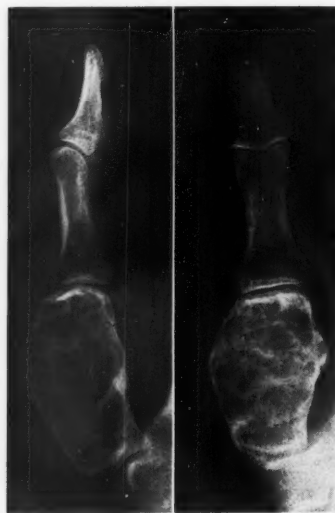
Case 31: Giant-cell tumor of right first metacarpal with pathologic fracture before and five years after roentgen therapy. No biopsy. The reossification is not yet complete.
